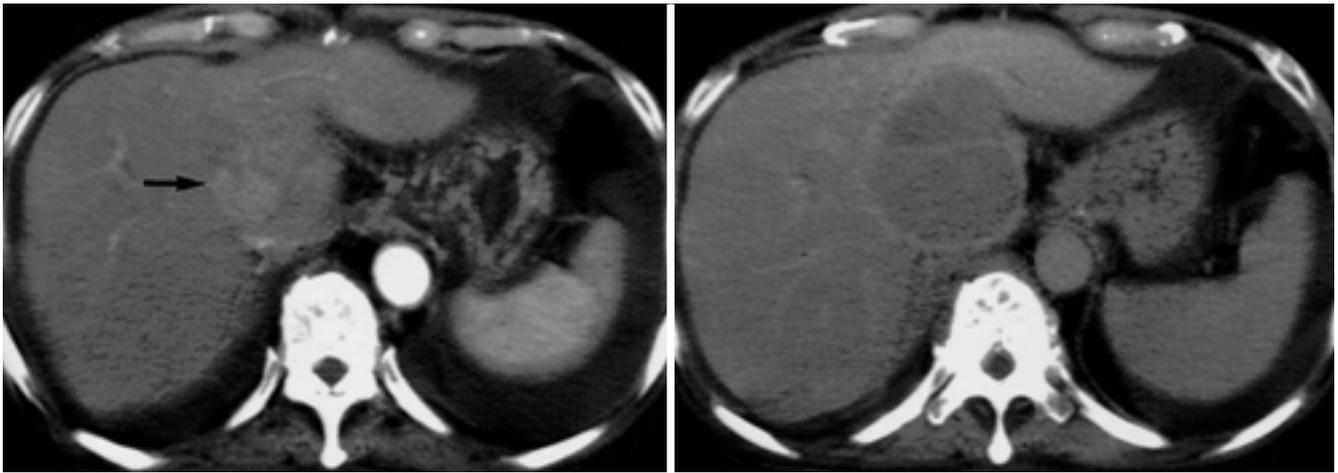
Secondary non-Hodgkin's lymphoma(NHL) in a 74-year-old man. Early phase CT(A) shows about 7 cm sized lobulated heterogeneous enhanced mass(arrow) in caudate lobe of liver. Late phase CT(B) shows low attenuation mass.
